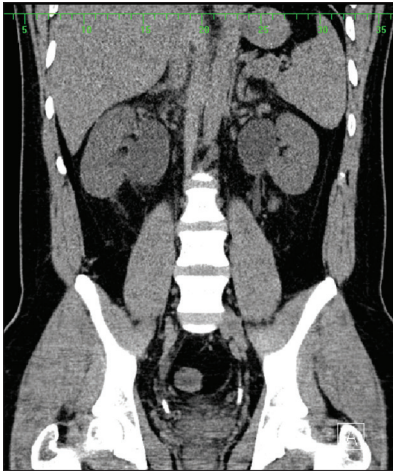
Noncontrast spiral computed tomography of the abdomen confirmed bilateral steinstrasse with subsequent bilateral hydroureteronephrosis
